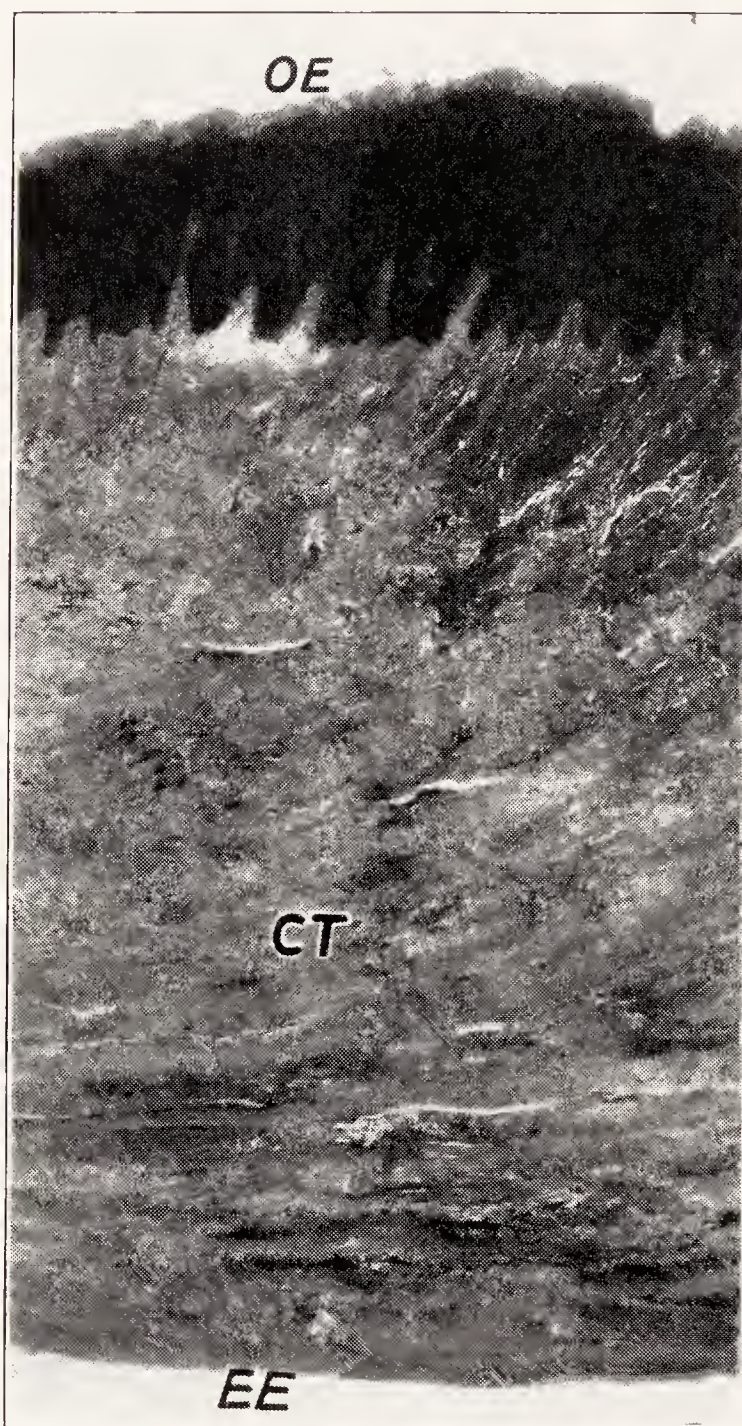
Higher magnification of area 1 in Figure 372. Tissue overlying crown of completely embedded tooth. *OE*, oral epithelium; *CT*, dense fibrous connective tissue of lamina propria and tooth follicle; *EE*, enamel epithelium. (Logan, Jour. Am. Dent. Assn.)
